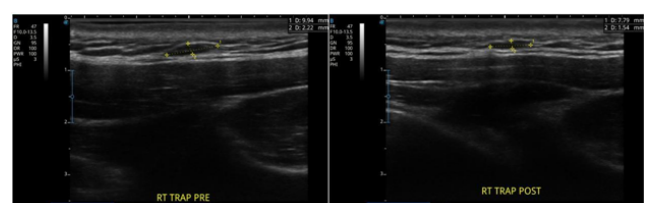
Example of pre- and post-intervention ultrasound study.
